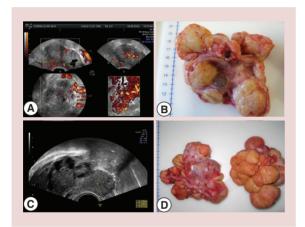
Undifferentiated serous ovarian carcinoma. (A) 3D color Doppler; (B) external surface; (C) B-mode, and (D) internal macroscopy of an undifferentiated serous ovarian carcinoma.
